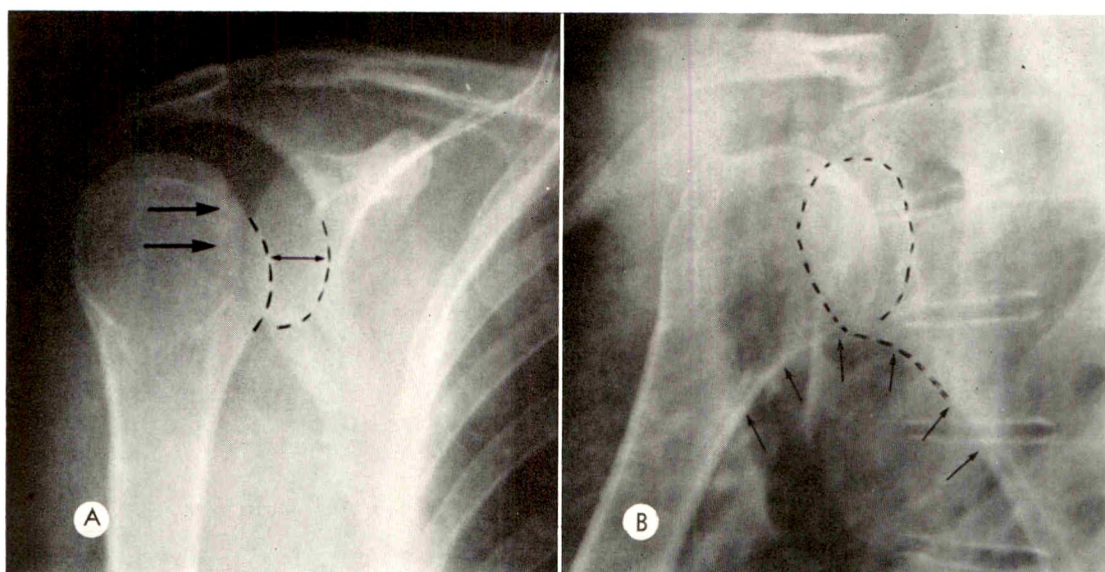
Case III. (A) Positive rim sign. Joint space ( $\leftrightarrow$ ) measured 12 mm. Compression fracture of internally rotated humeral head (arrows) is evident. (B) Postreduction transthoracic lateral roentgenogram demonstrates the restored glenohumeral relationship and the normal broad scapulohumeral arch. Compare with Figure 2B.
